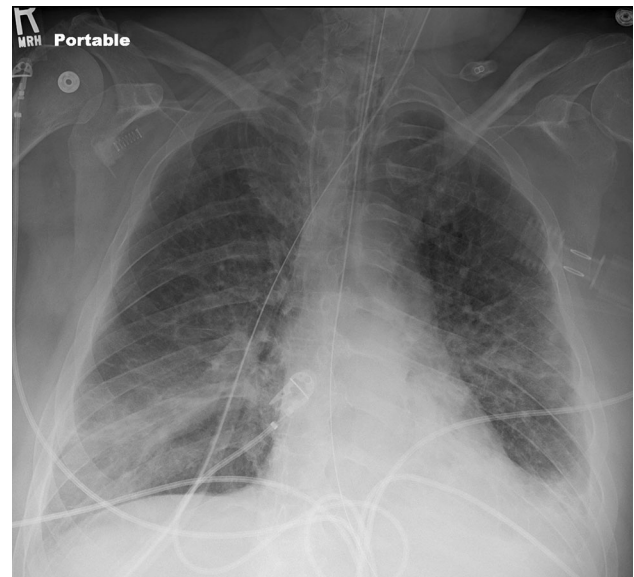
A 45-year-old male with H1N1 influenza who required intubation. Focal consolidation in the right lower lobe on chest radiograph is consistent with superimposed bacterial pneumonia
